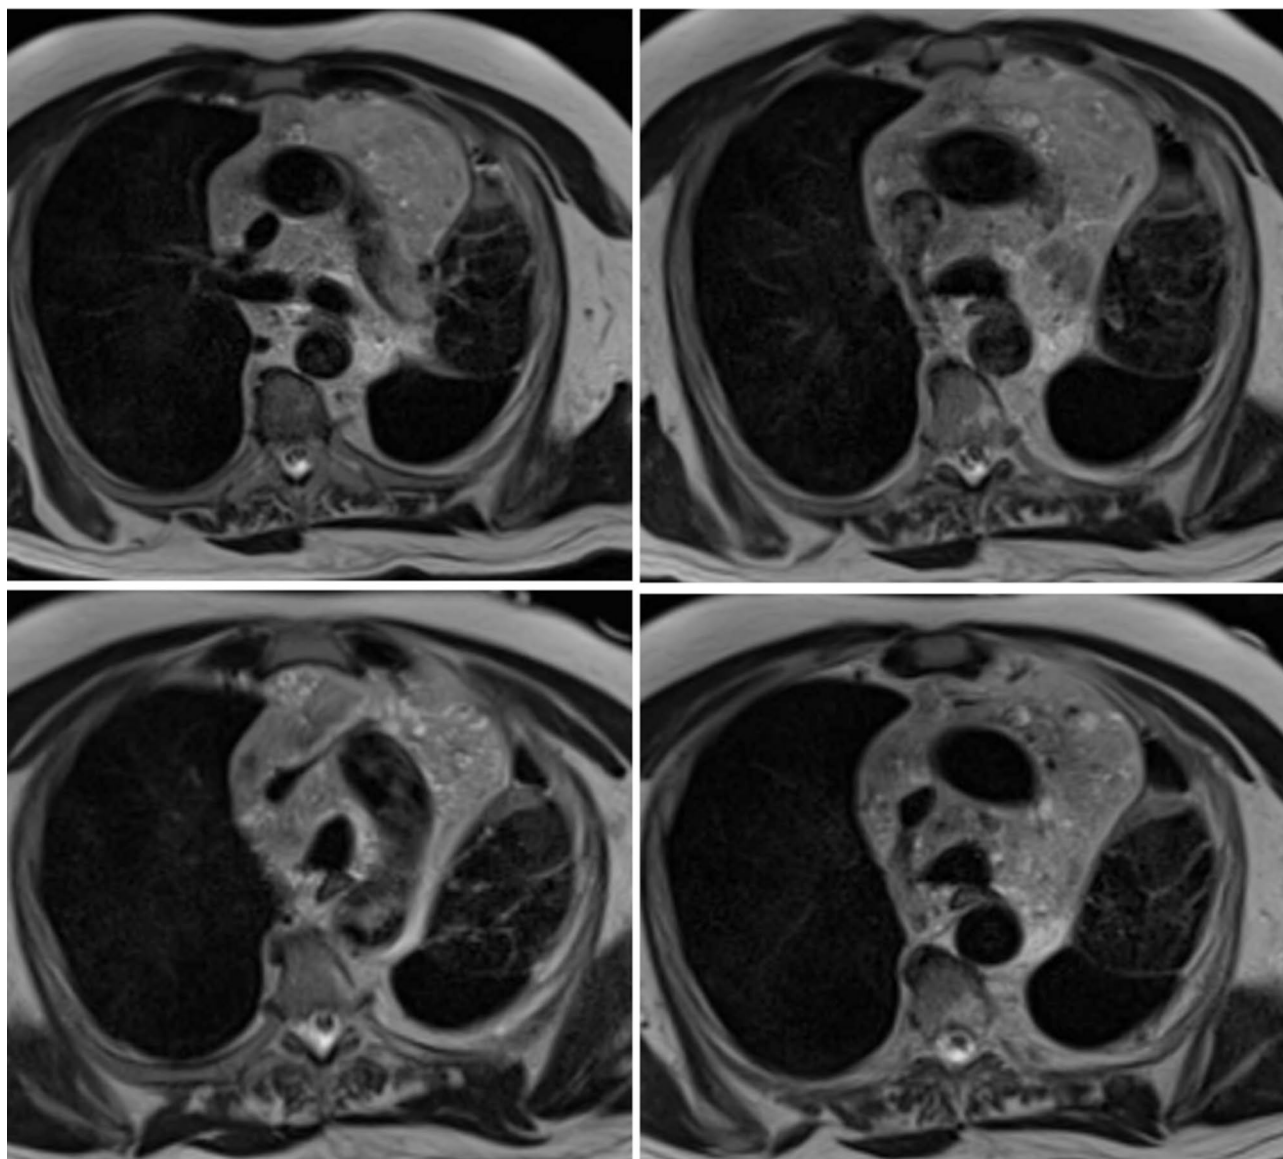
MRI of the Chest showing mediastinal lymphatic malformation with moderate compression on the superior vena cava
